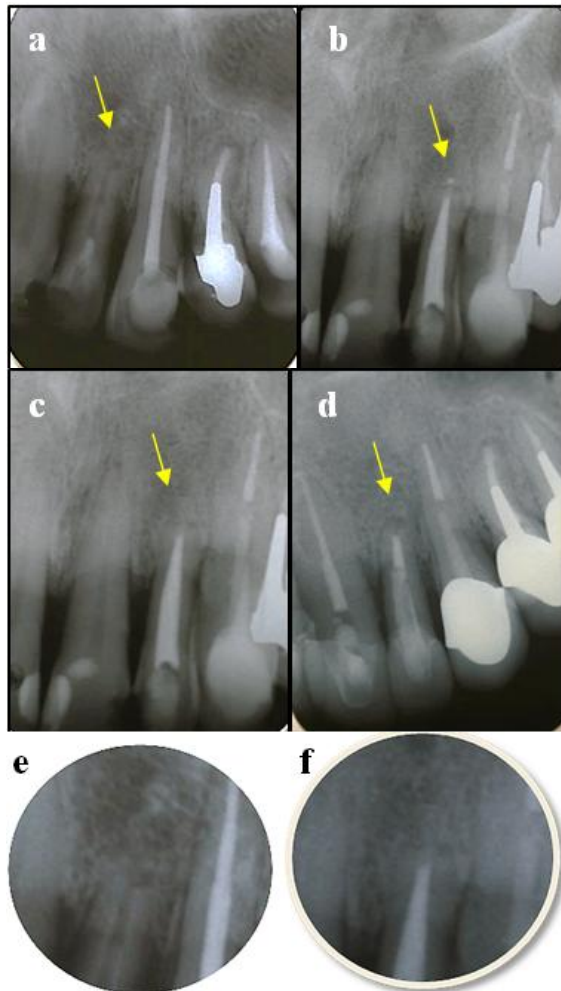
a/initial x-ray presents the periapical condition of tooth 22 after apical surgery 9 years ago; b/control x-ray after obturation using biphasic calcium phosphate ceramic as a apical barrier and AH Plus as a sealer and gutta-percha; c/control x-ray at 6th month; d/control x-ray after FRC post placement e/ zoom at initial clinical situation; f/zoom at 4th year after definitive obturation.
